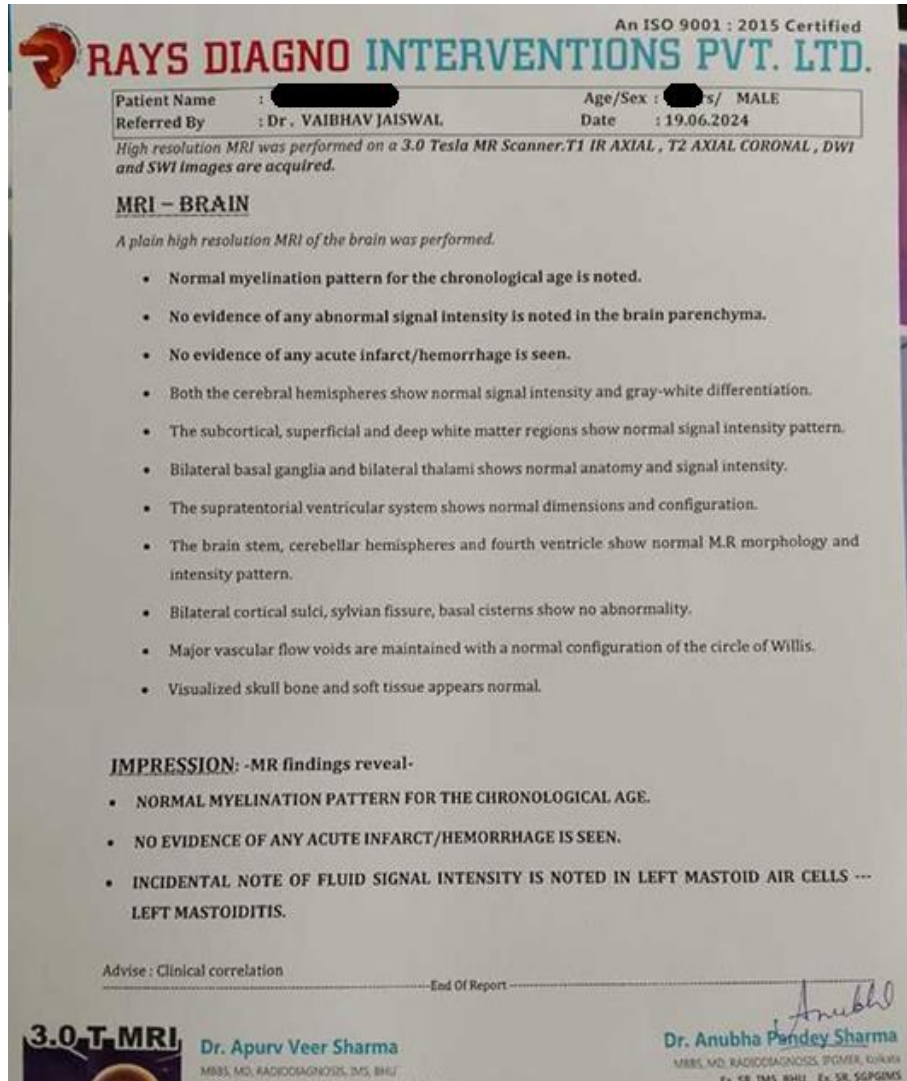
MRI BRAIN - No Structural abnormality
